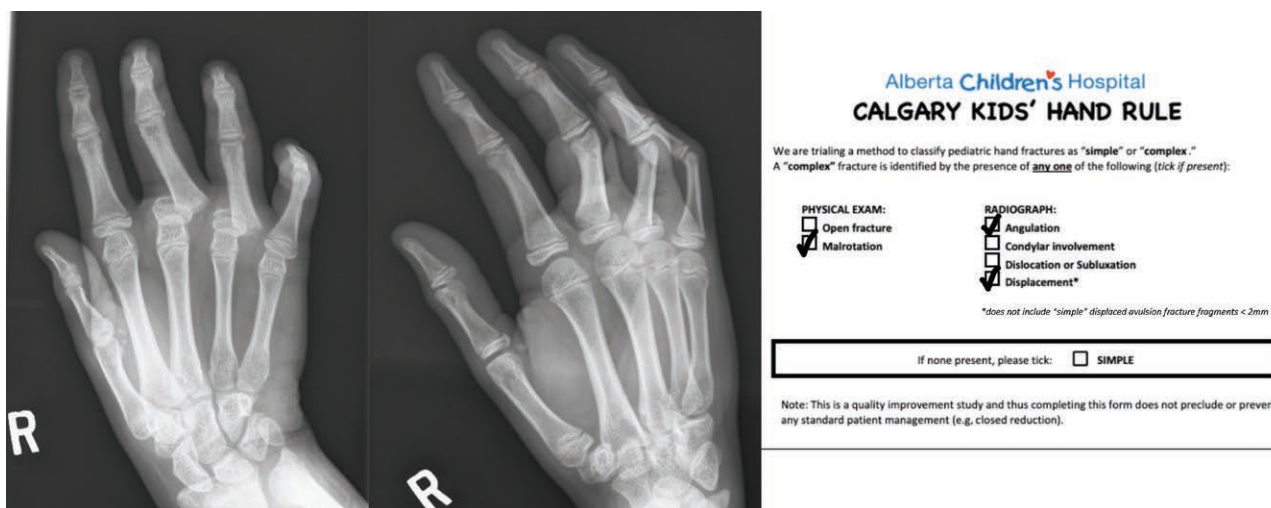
Example of a clinical tool adapted from the prediction model for complex fractures with a threshold of ≥ 1 point and how to apply this clinical tool using a sample radiograph.
